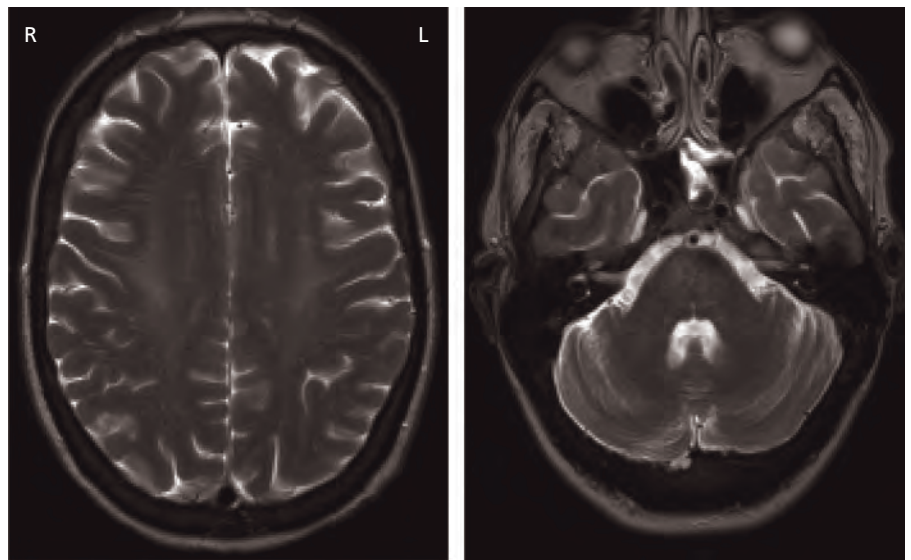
Central pontine myelinolysis showing extensive pontine and extrapontine demyelination (MRI T2W).
